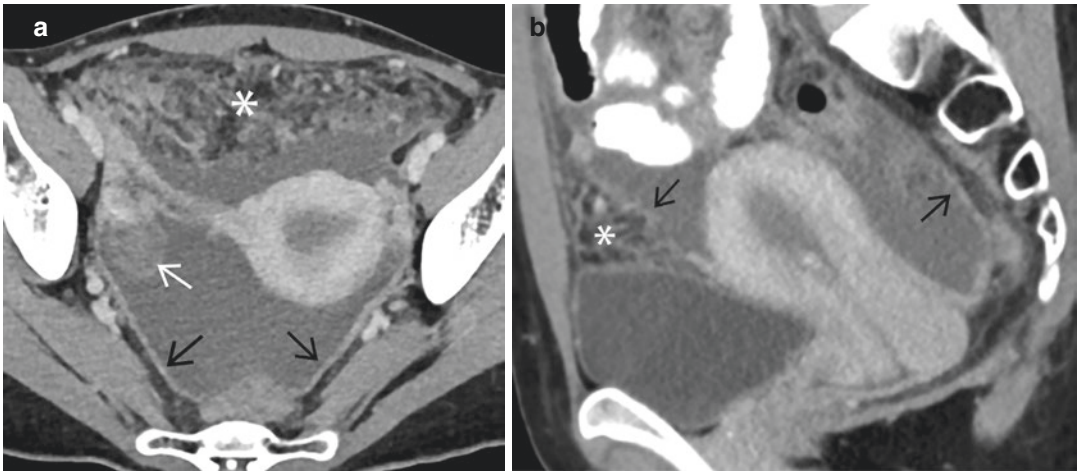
Endometrial and right ovarian TB in a 38-year-old woman who had peritoneal TB. (a) Axial and (b) sagittal contrast-enhanced CT images show a prominent uterus with a fluid-filled uterine cavity and a prominent
